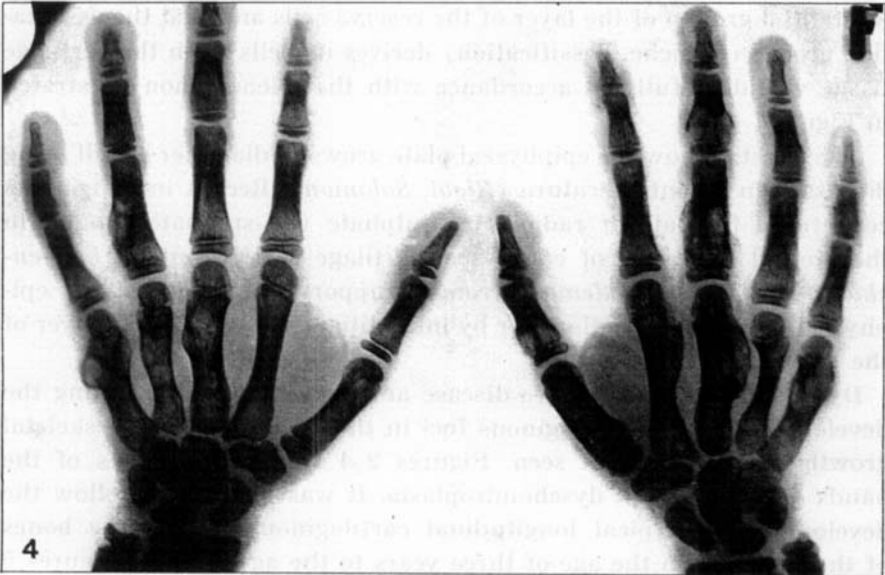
Radiograph of the same hands as seen in Figures 2 and 3. Age nine years.
